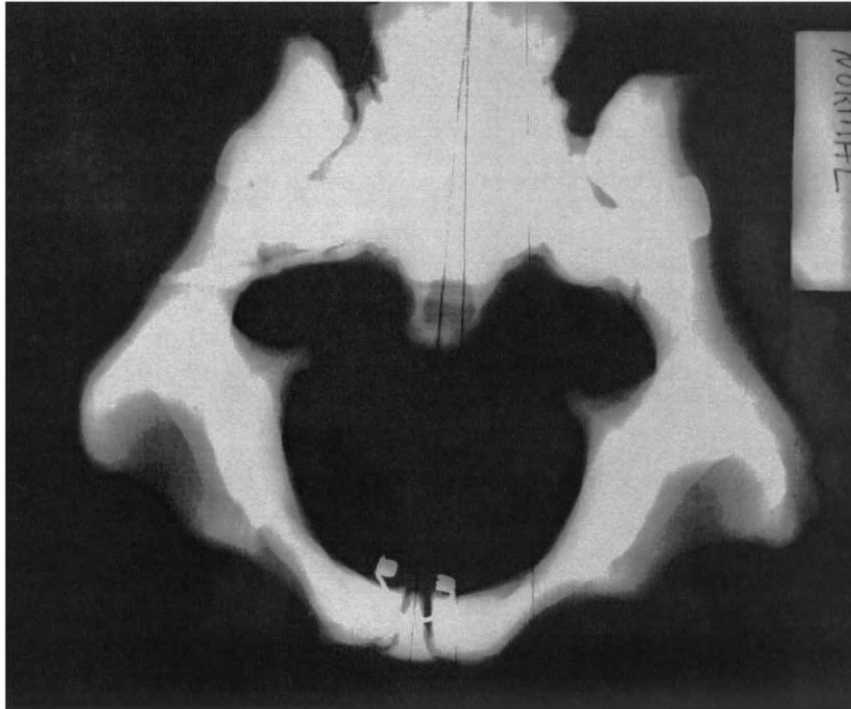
Normal unsubluxated female pelvic bowl. (Model) S to I view. Note symmetry and relative roundness of opening. (Radiograph provided courtesy of Cherie Goble, DC.)
